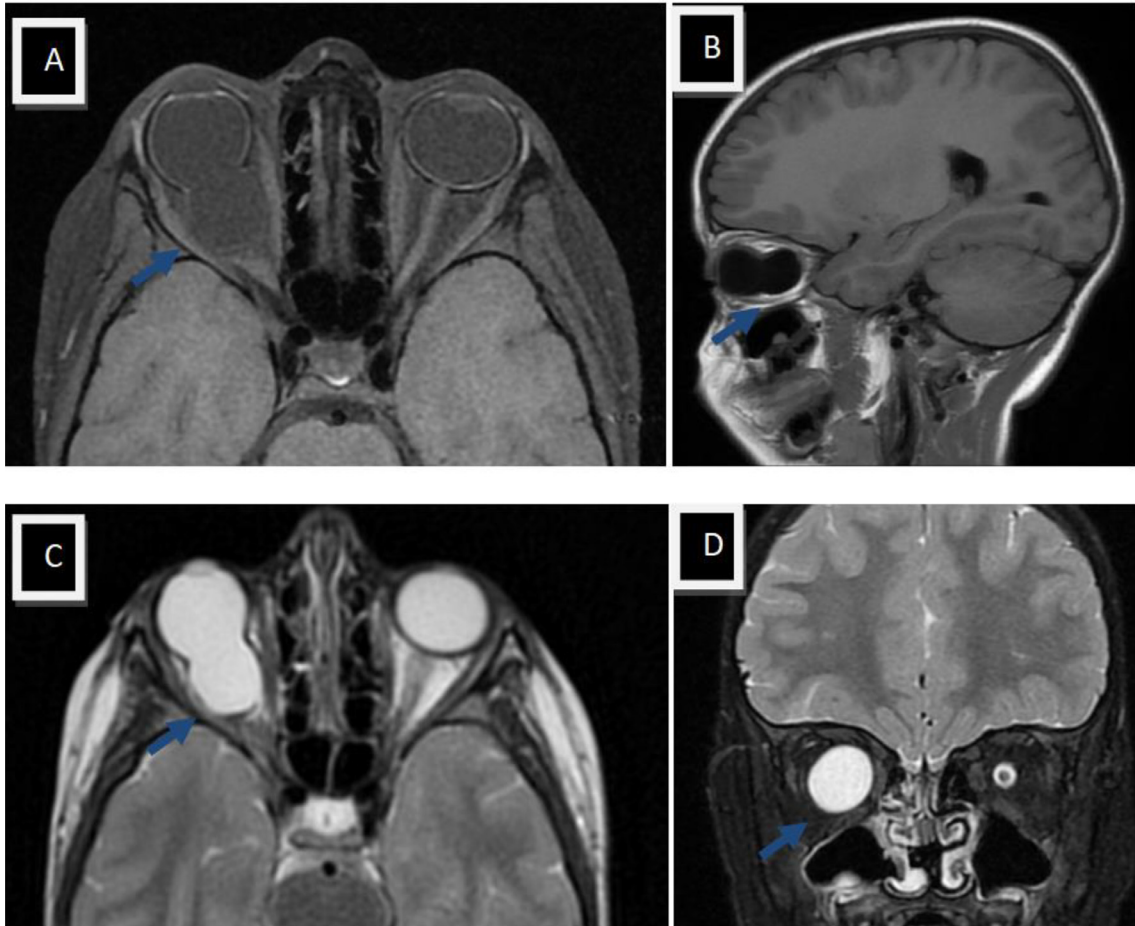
(A) Axial T1W, (B) sagittal T1W, (C) Axial T2W, and (D) coronal T2W MRI image, showing identified a T1 hypointense and T2 hyperintense lesion, corresponding to a retrobulbar, intra-conal cystic cavity that completely replaced the optic nerve (blue arrow).
